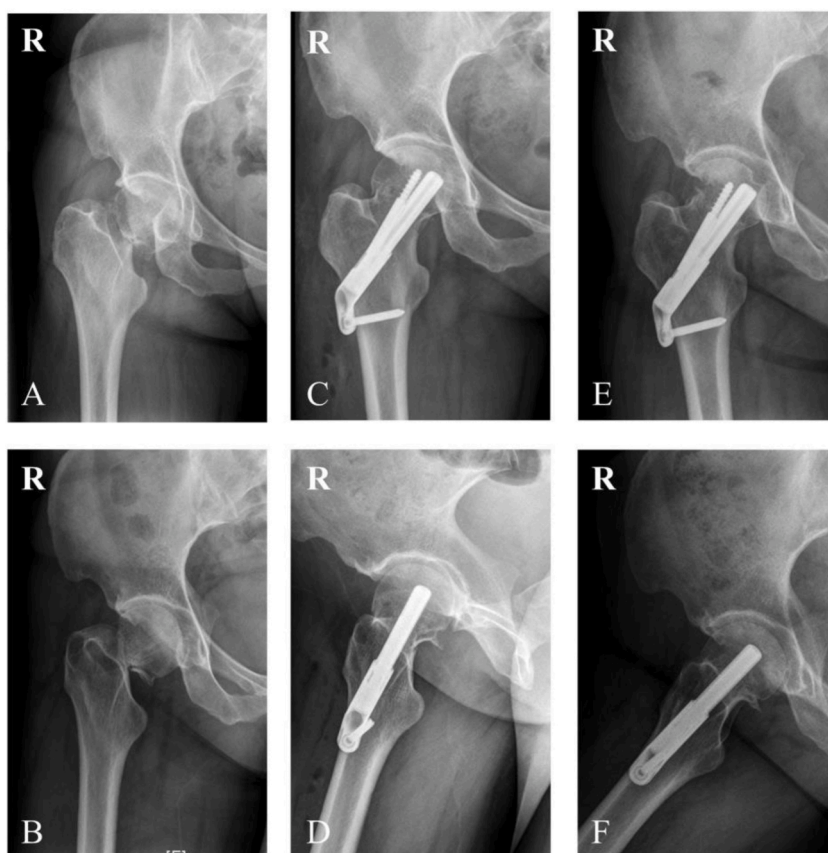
A 49-year-old female with a right femoral neck fracture underwent FNS fixation. (A, B) Preoperative radiographs showed the fracture of Garden type VI; (C, D) postoperative radiographs; (E, F) 6 months after surgery, the fracture healed well with moderate shortening of the femoral neck.
